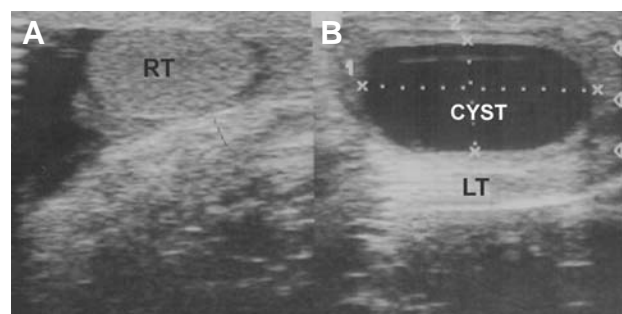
Preoperative ultrasound assessment. A) Normal right testis (RT). B) Cyst and compressed left testis (LT).
